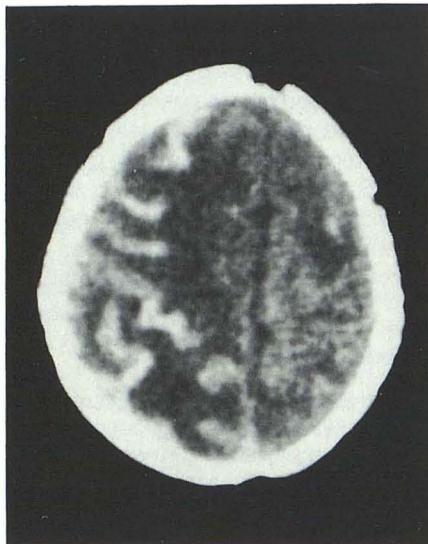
Unenhanced CT scan at 3 months after presentation. Widespread low-density cystic changes in cerebral hemispheres.
